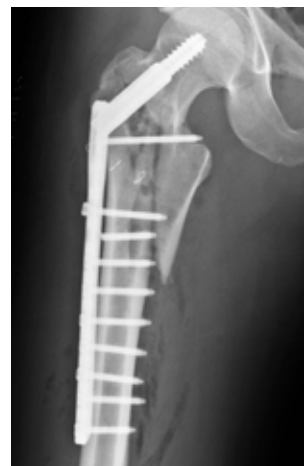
Fixation was achieved with a sliding hip screw. Postoperative anteroposterior radiograph (day 0) shows stable fracture reduction, stable-appearing instrumentation, and screw fixation.
